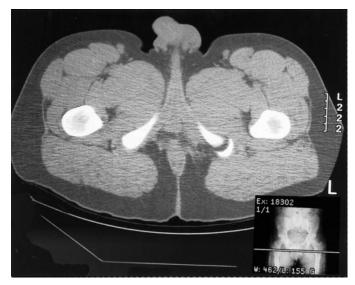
Computed tomography scan showing an ischial tuberosity avulsion fracture displaced approximately 1.2 cm.
